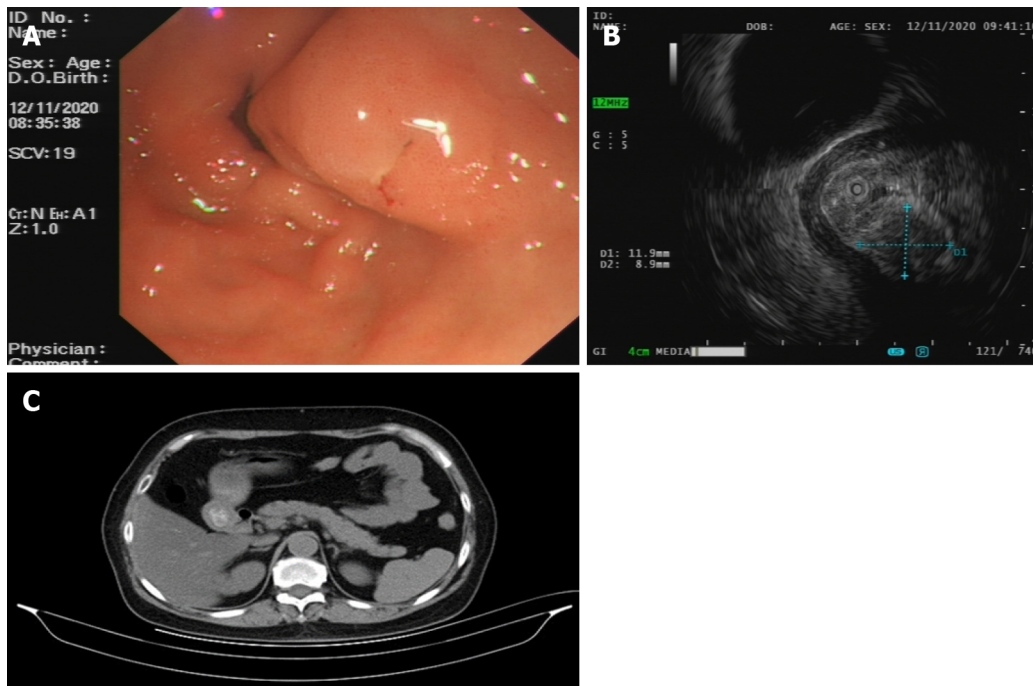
Preoperative imaging examinations. A: Gastroscopy revealing a submucosal protuberance of the gastric antrum; B: Endoscopic ultrasonography indicating a round mixed echogenic mass with a size of approximately 1.19 cm × 0.89 cm; C: Abdominal computed tomography scan showing no obvious abnormal thickening or enhancement shadow of the gastric antrum.
